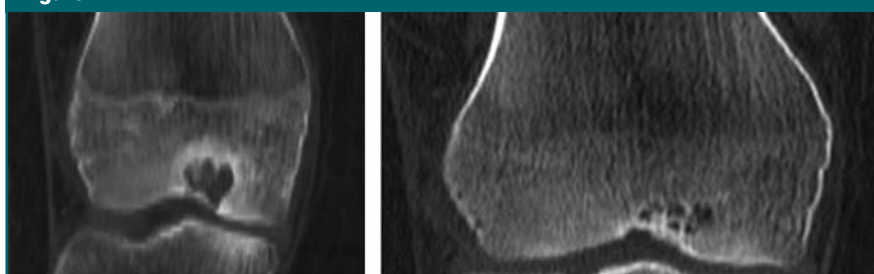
CT scans in 14-year-old adolescent boy demonstrate healing of a lesion after RF ablation. (a) Coronal reconstructed CT scan of the knee obtained 3 months after ablation demonstrates a small lytic lesion with sclerotic margins along the inner margin of the medial femoral condyle with thinning of the articular surface. (b) CT scan obtained 24 months later demonstrates healing in the area of the lesion with in-growth of bone and small residual cystic change.
